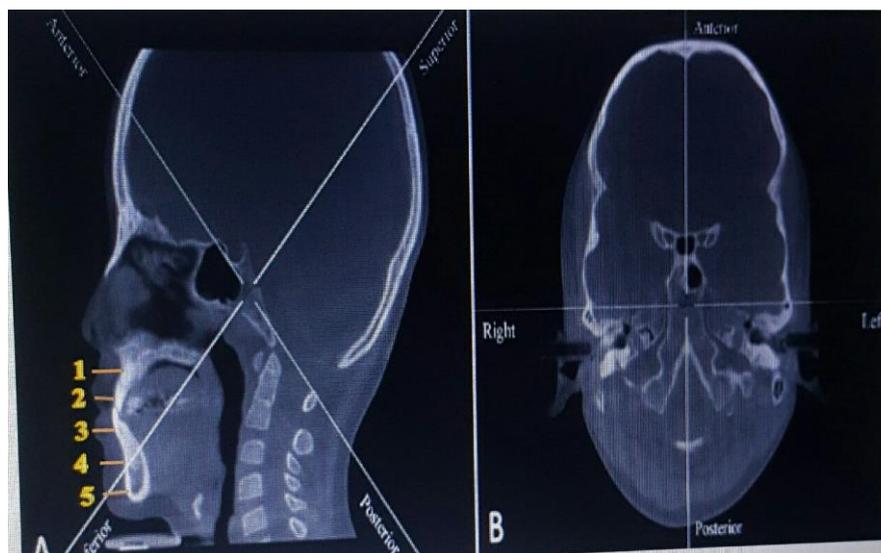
soft tissue measurements on sagittal section of CBCT
